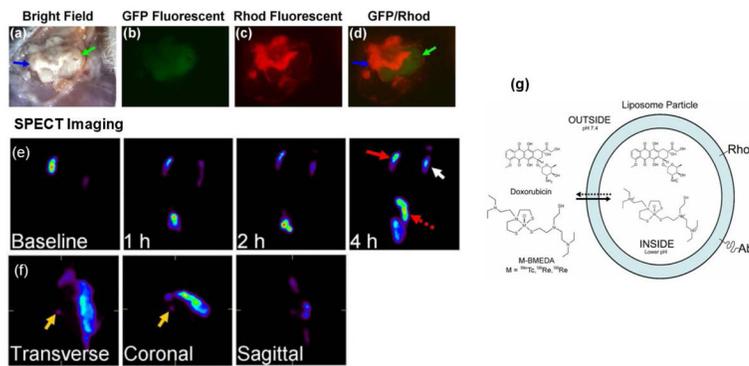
Receptor targeted radioactive immunoliposomes for SPECT imaging of residual breast tumors in lumpectomy cavity and draining lymph nodes
